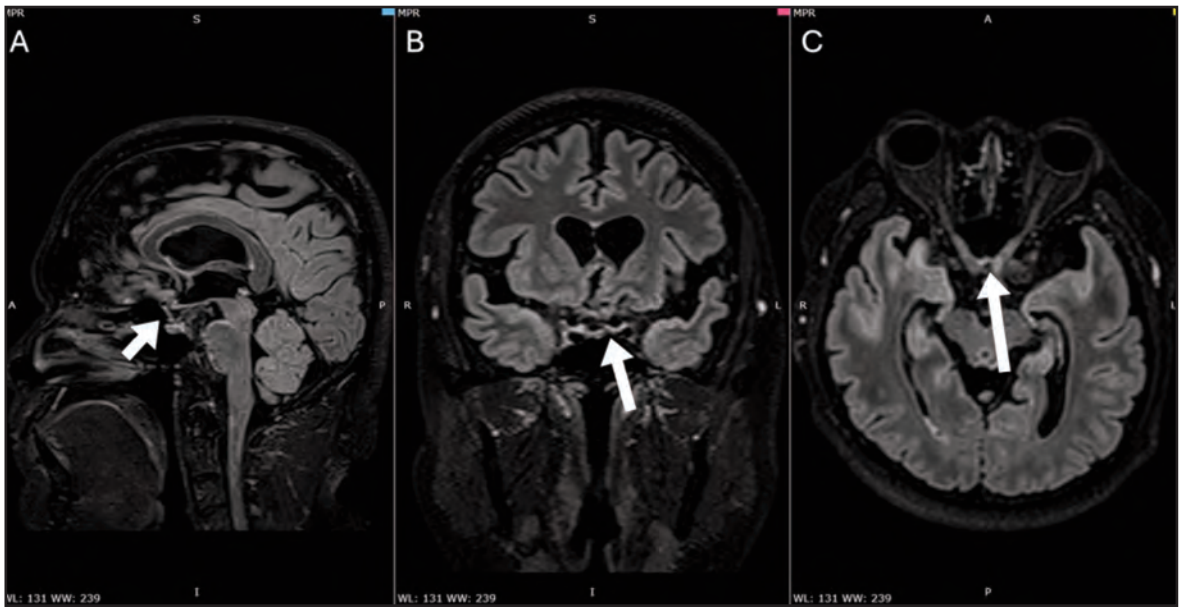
T2/FLAIR MRI brain and orbit images showing hyperintensity in the optic chiasm (arrow)
